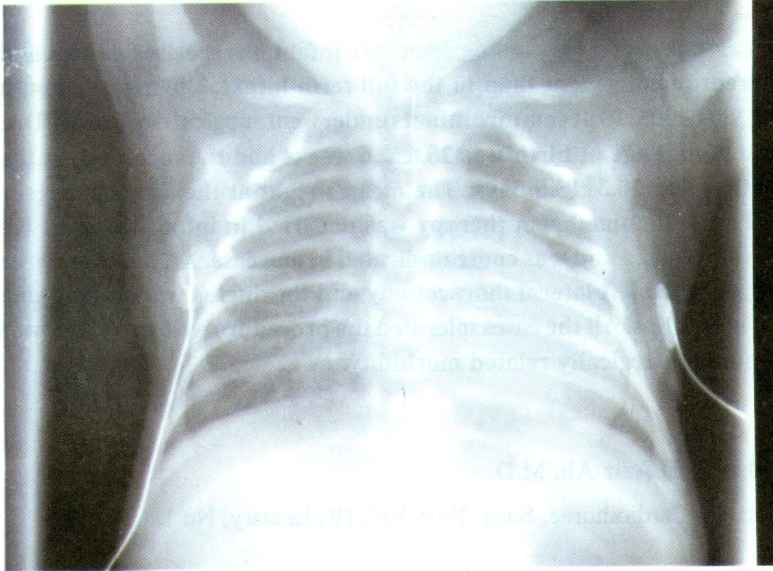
Preoperative chest X-ray showing cardiomegaly and severe pulmonary congestion (patient is intubated).
